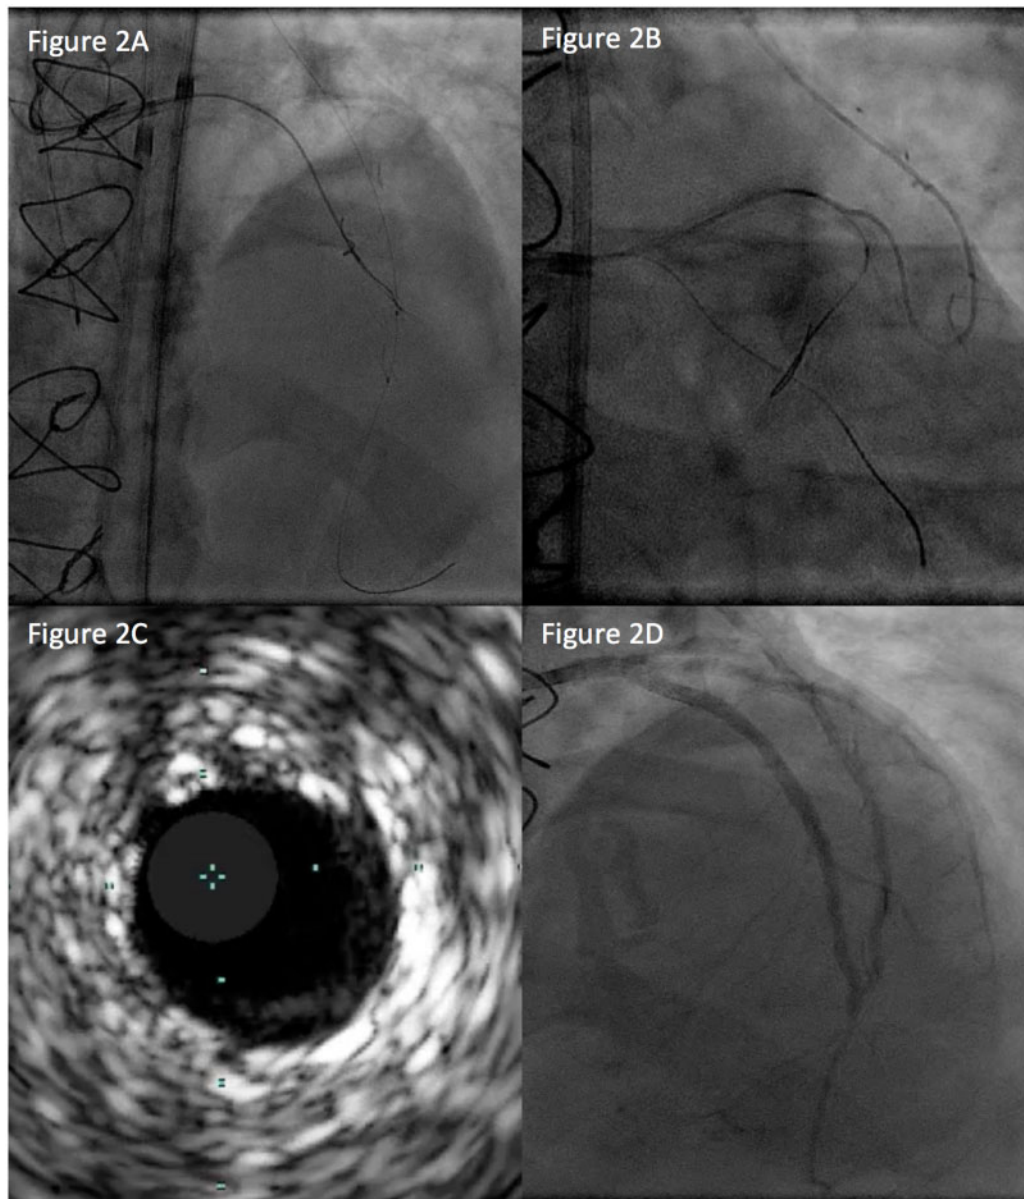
Zero-iodinated contrast gadolinium-based chronic total occlusion percutaneous coronary intervention of left anterior descending artery. Chronic total occlusion percutaneous coronary intervention of left anterior descending artery was successfully performed without use of iodinated contrast. Antegrade wire escalation and antegrade dissection re-entry failed to cross the lesion (A). The chronic total occlusion segment was successfully crossed retrogradely with reverse controlled antegrade and retrograde tracking strategy using left internal mammary artery to left anterior descending artery as retrograde conduit (B). Intravascular ultrasound-guided stent optimization was performed (C). No contrast (iodinated or gadolinium) was used till this stage. Post-percutaneous coronary intervention gadolinium contrast angiography confirmed Thrombolysis In Myocardial Infarction grade 3 flow in left anterior descending artery (D, see [Supplementary material online, Video S2](#)).
